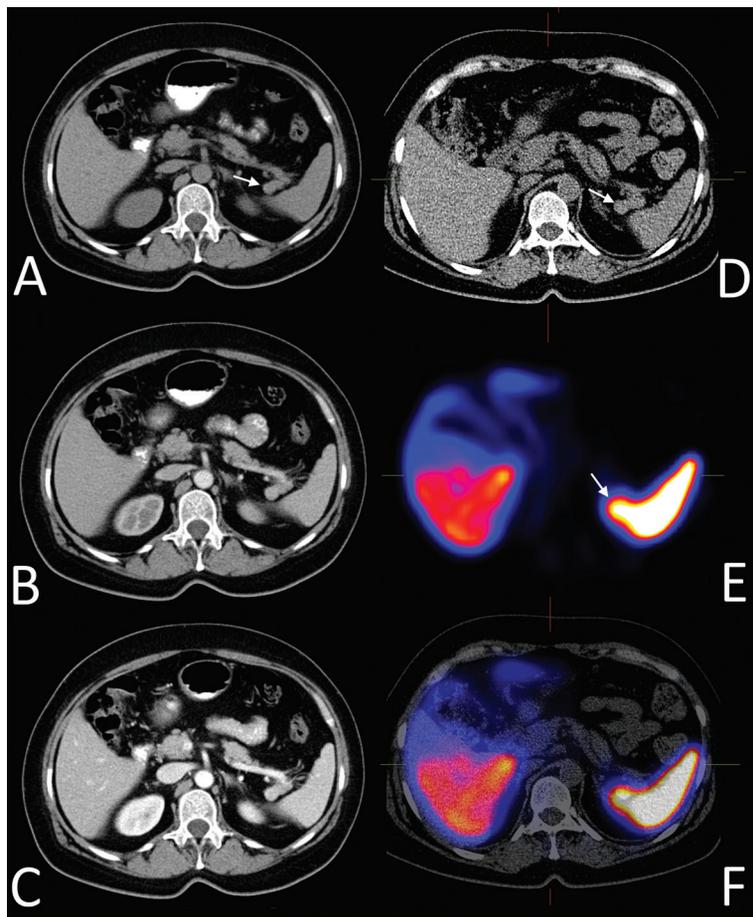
Patient 1. Similarly to Figure 1. A, B, C, D. Note radiotracer uptake in both “main” and accessory spleens is indistinguishable in pure single photon emission computed tomography (SPECT) scan (E). SPECT/CT fused images (F) clearly show the source of activity in the accessory spleen located behind the pancreatic tail (arrow).
